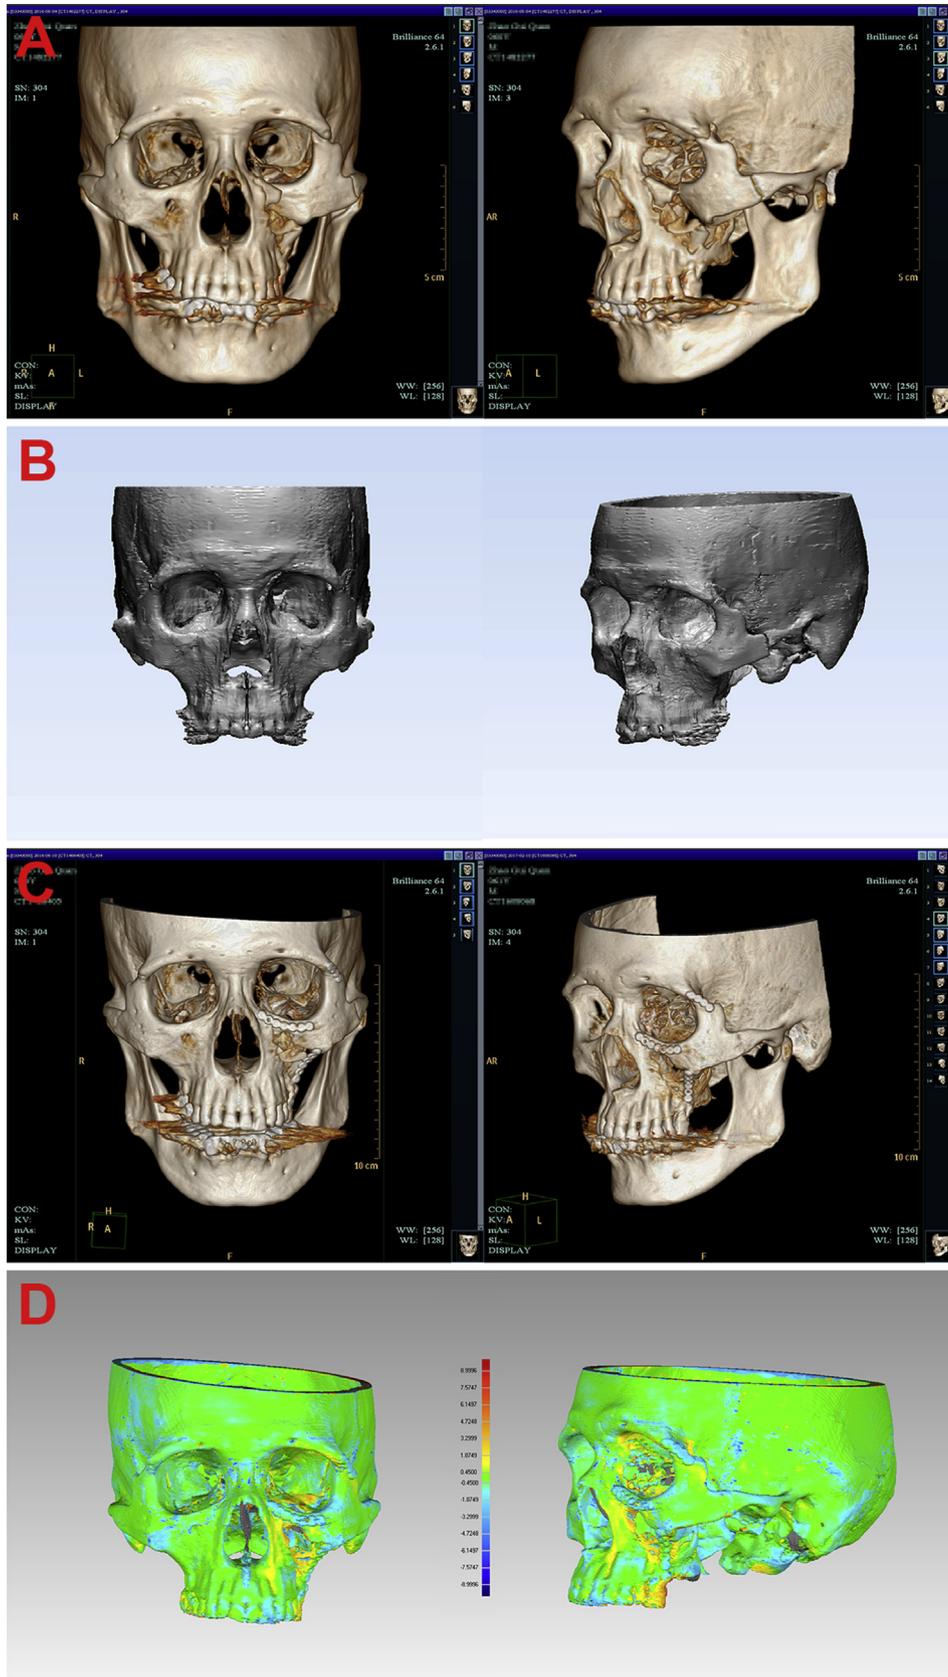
The outcome of navigation-assisted ZMC reduction. (A) Preoperative three-dimensional (3D) computed tomography (CT) of ZMC fracture. (B) Virtual plan made by mirroring of the healthy contralateral ZMC. (C) Postoperative 3D CT. (D) Chromatographic analysis of the virtual plan and postoperative CT image.
